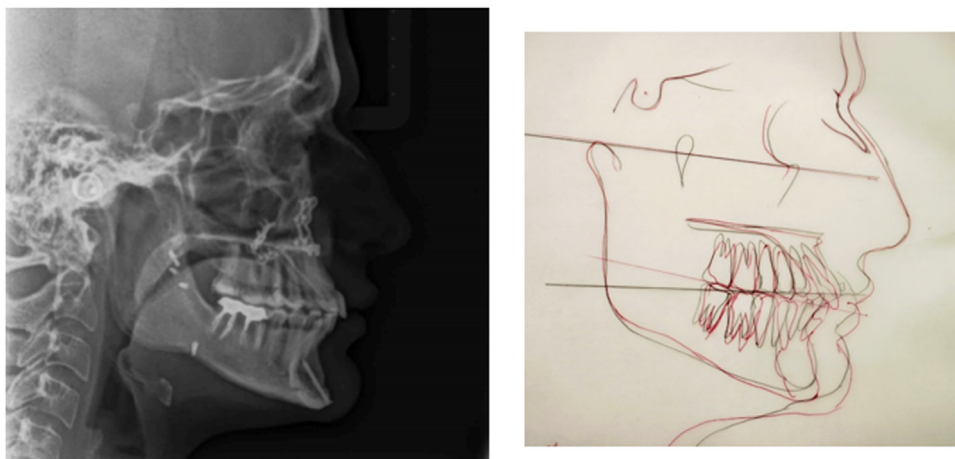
Patient 3. Posttreatment lateral cephalometric radiograph and tracing.
